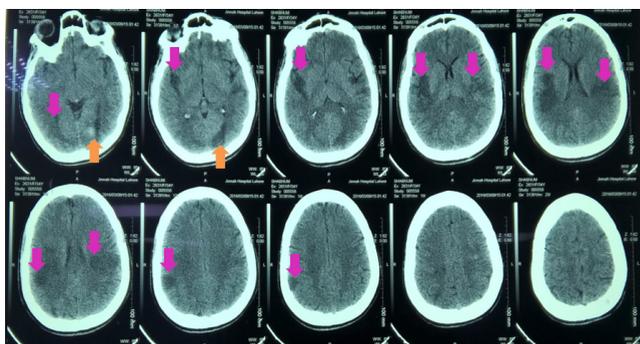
CT scan Brain of the patient
